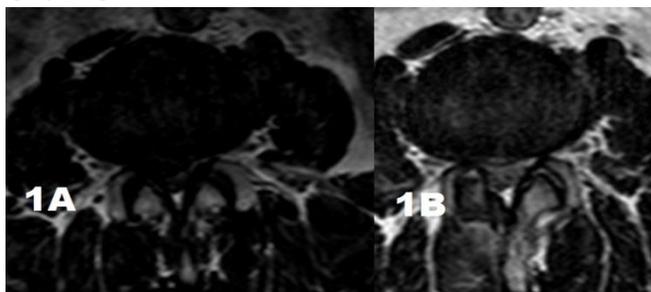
Axial T2-weighted magnetic resonance image through the L3-L4 disc showing the right mediolateral disc herniation (1A), postoperative lumbar MRI one month later after surgery (1B)
